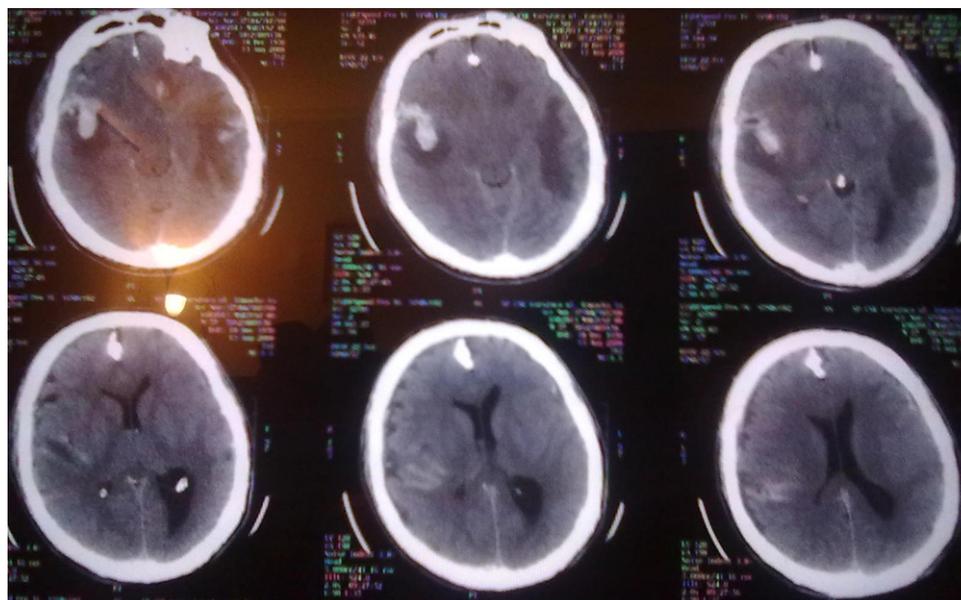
Cranial CT scan on the first day following the injury.
